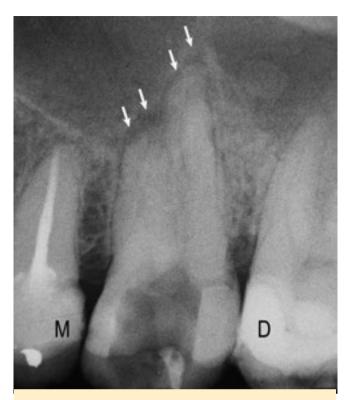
Preoperative periapical radiograph of the left maxillary first molar showing severe calcification of the root canals and periapical radiolucencies (arrows). M, mesial side; D, distal side.
